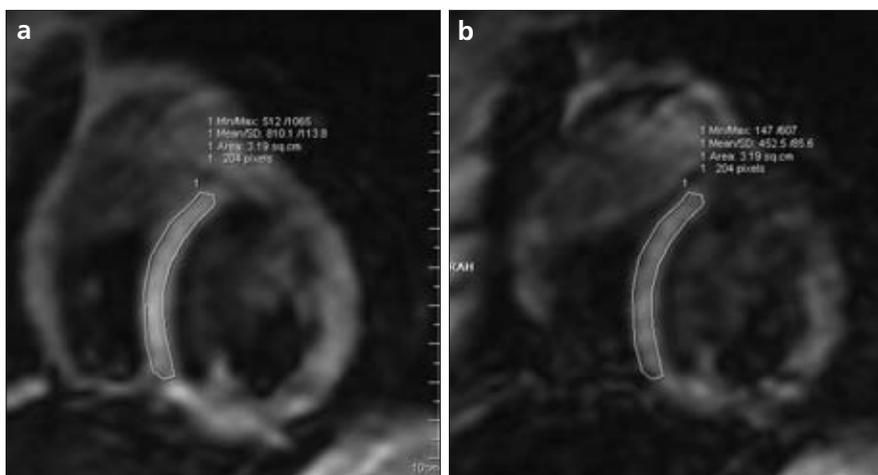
a, b. MR images showing the contour drawn over the septum for the calculation of T2*.
